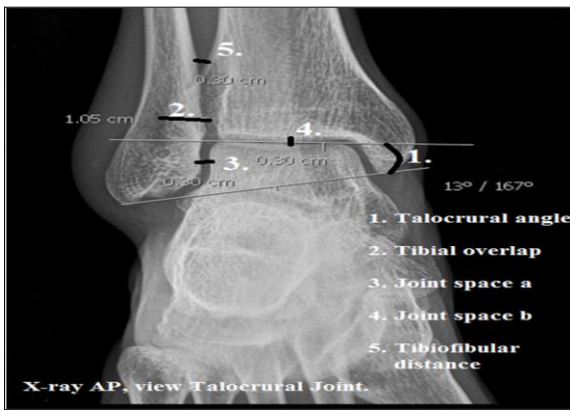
X-ray AP, view Talocrural Joint.
